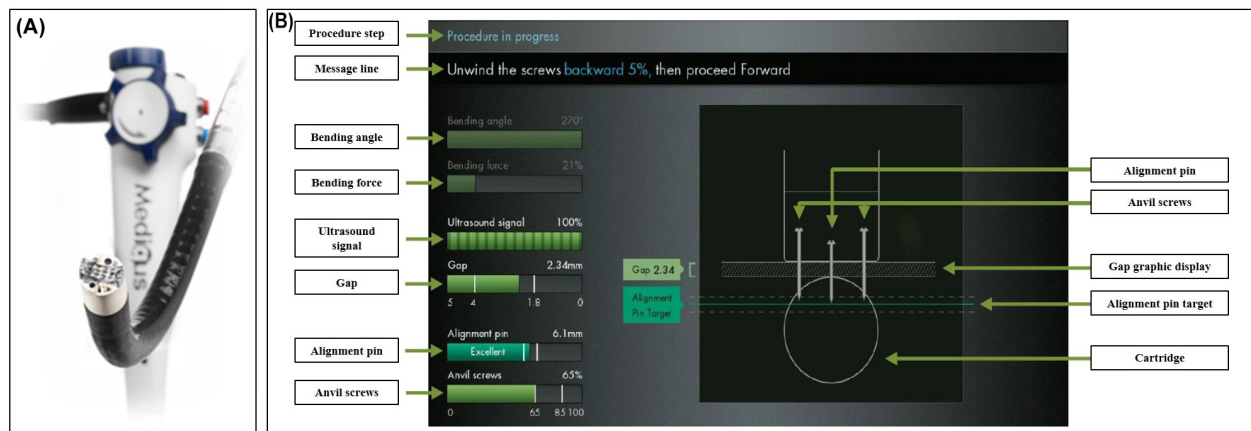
Details of the MUSE device (courtesy of Medigus, Omer, Israel). (A) A handle, housing the controls; a 15.5 mm diameter and 66 cm long insertion tube, containing suction and insufflation/irrigation channels, and electrical and mechanical cables; a 66 mm long rigid section containing the cartridge. (B) The endostapler contains a controller for the camera, ultrasonic range finder, and various sensors (bending angle, bending force, alignment pin, anvil screws, gap).
